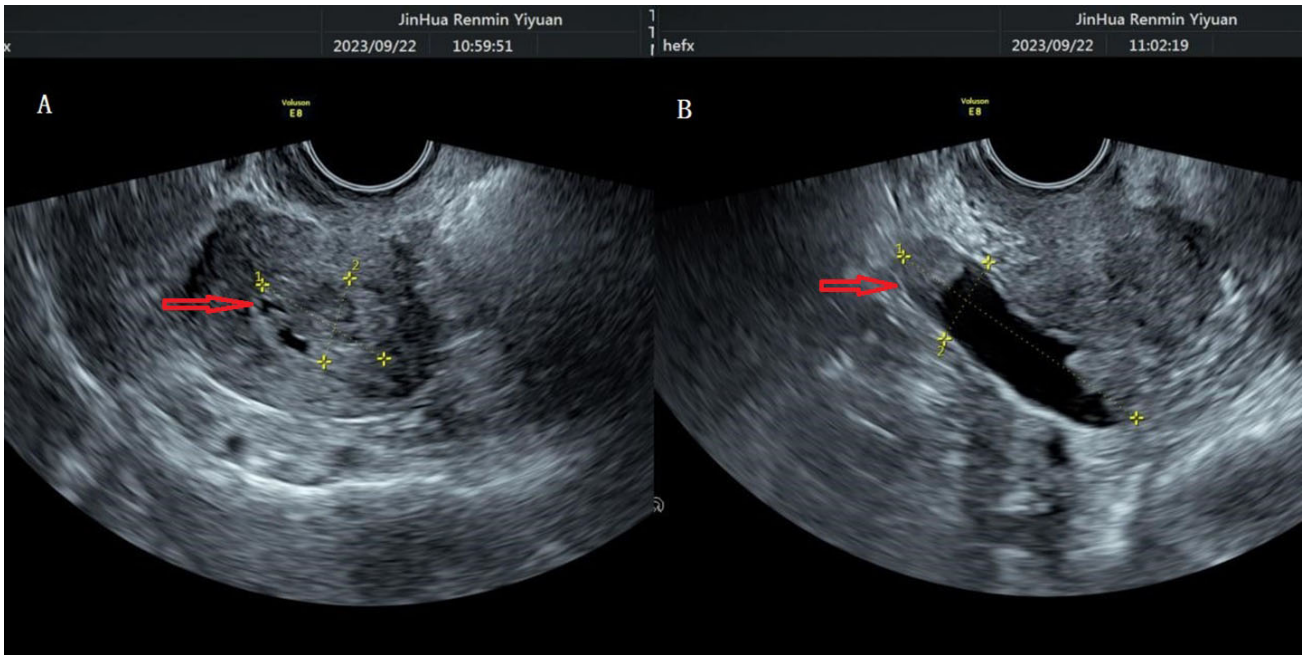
Ordinary color Doppler ultrasound examination film of the patient. (A) Uterine mass. (B) Ovarian cyst. The red arrow points to an uneven mass/mass in the uterine cavity.
